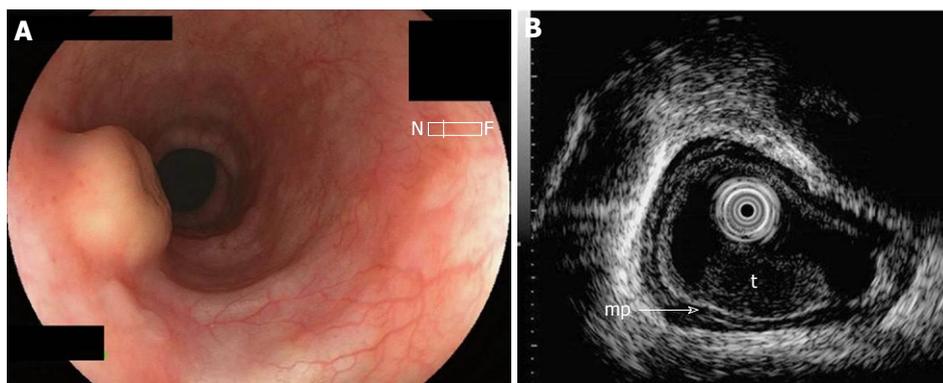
Pretherapeutic examinations of esophageal granular cell tumor. A: Endoscopic view of the yellowish submucosal tumor with a central depression in the middle esophagus; B: Endoscopic ultrasonography showing a hypoechoic solid tumor (t) in the submucosa; Arrow-mp: Muscularis propria.
